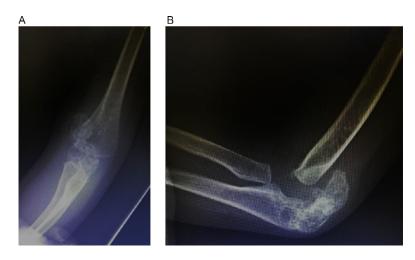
Right elbow AP (A) and lateral (B) radiograph, obtained at 2 years and 4 months of age, demonstrating an ossified mass protruding from the proximal aspect of the ulna.
